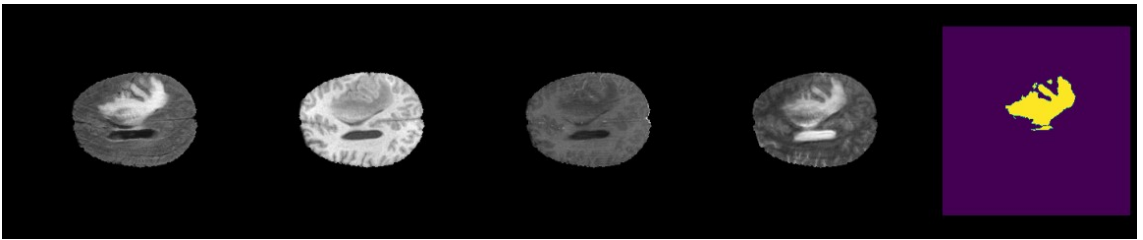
MRI modalities and ground mask
